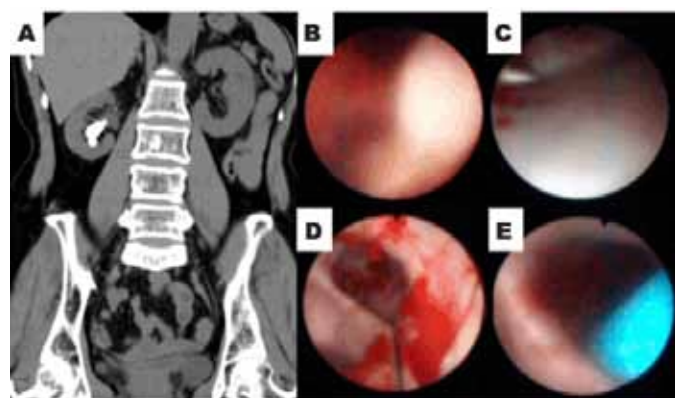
(A) Preoperative axial CT. Ureteroscopic findings, (B) The renal stone occupied the lower pole. (C, D) Puncturing from the upper calyx to the skin, and (E) Dilation of the nephrostomy under ureteroscopic guidance.
